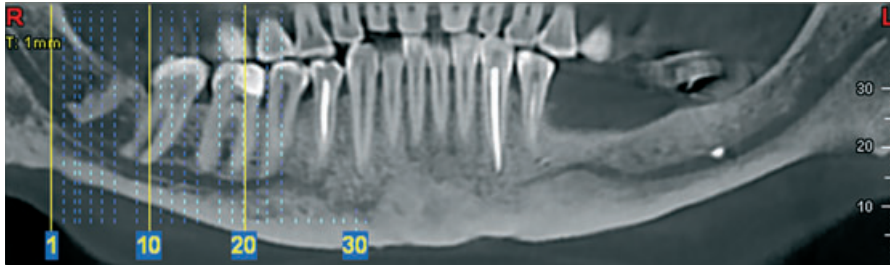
CBCT sagittal slice/cut through the filling material present into the mandibular canal.
